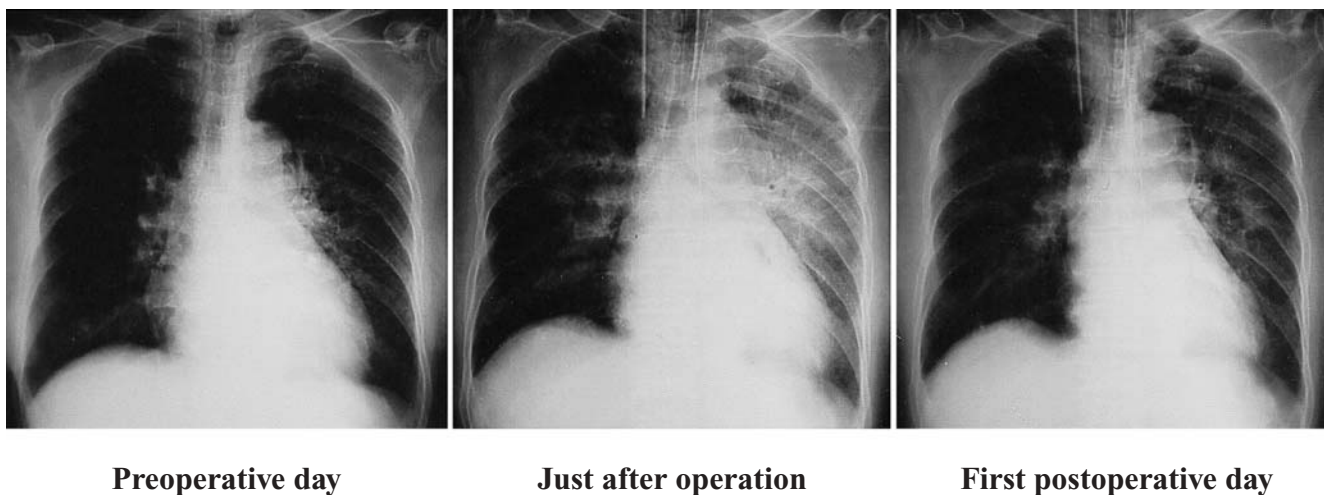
Chest x-ray findings of the patient. The chest x-ray showed diffuse shadow of lung infiltration, especially in the left lung just after the operation, which was markedly improved on the next postoperative day
